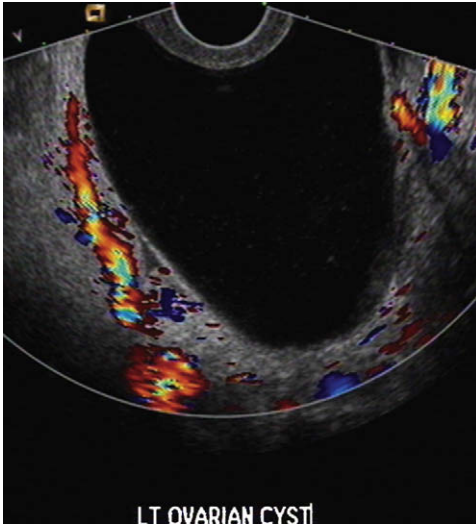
Simple ovarian cyst. Transvaginal color flow Doppler image demonstrates a large simple ovarian cyst.
